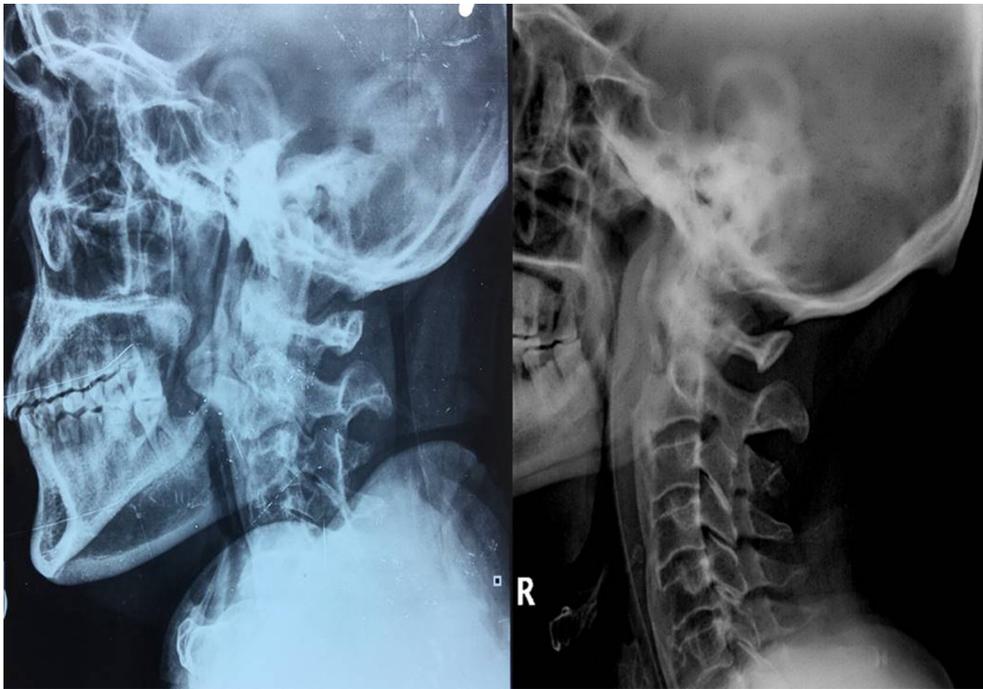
Preoperative X-ray Neck (left) & Postoperative X-ray Neck (Right).
